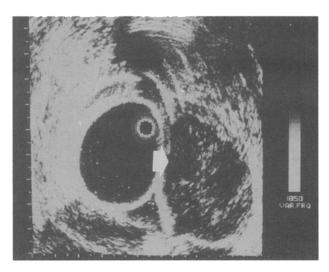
Patient 2. Endorectal ultrasound image showing a hypoechoic well-delineated tumor that involves the muscularis propria (arrow).
